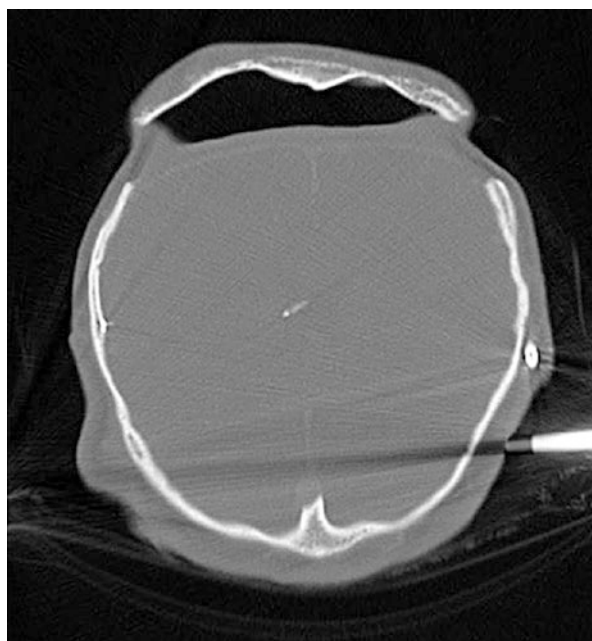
CT scan demonstrating retrofrontal dead space after monobloc distraction with a functioning V-P shunt
